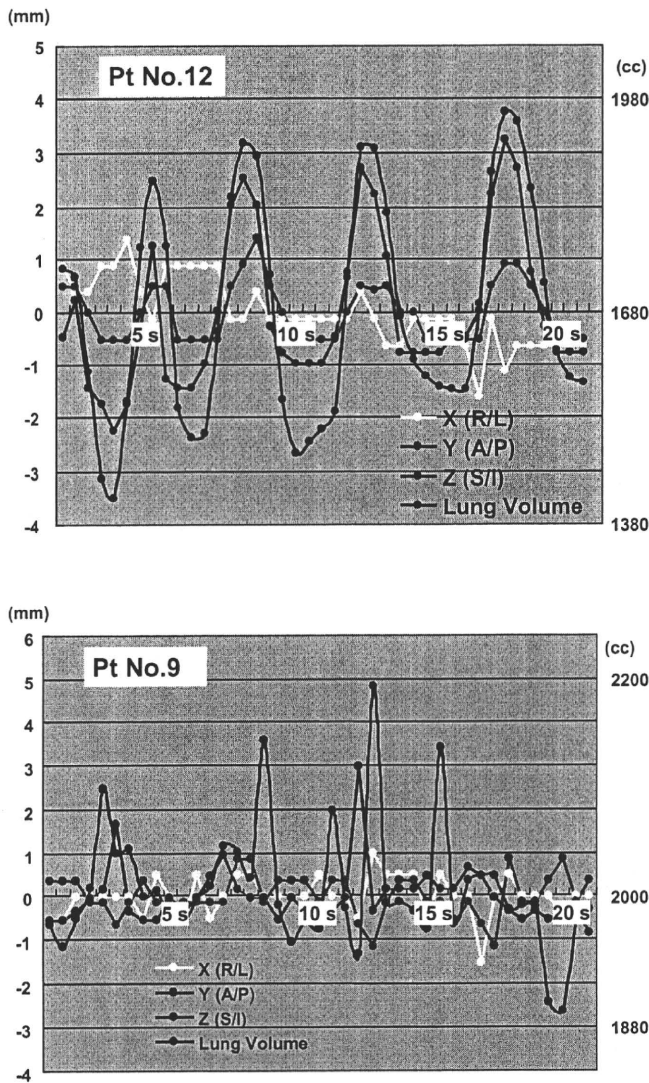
Metal clips' centroid trajectories in all 41 phases for 20 s of the four-dimensional CT scans. (A) Patient 12. (B) Patient 9. R/L = right-left; A/P = anterior-posterior; S/I = superior-inferior.
